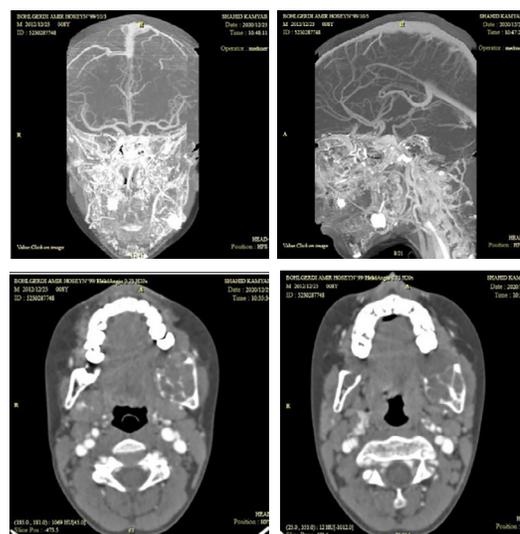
Images of CT angiography; the presence of a multilocular lesion with destruction of the left mandibular cortex is visible. No blushing or hemangioma is present.
